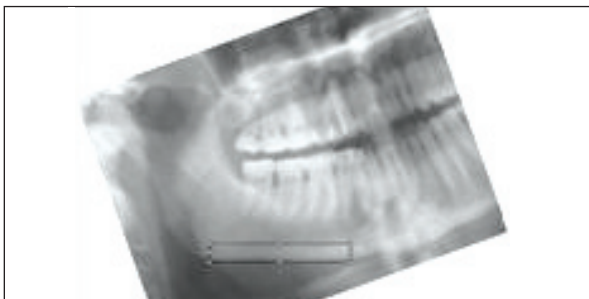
Rotated cropped panoramic radiograph.
